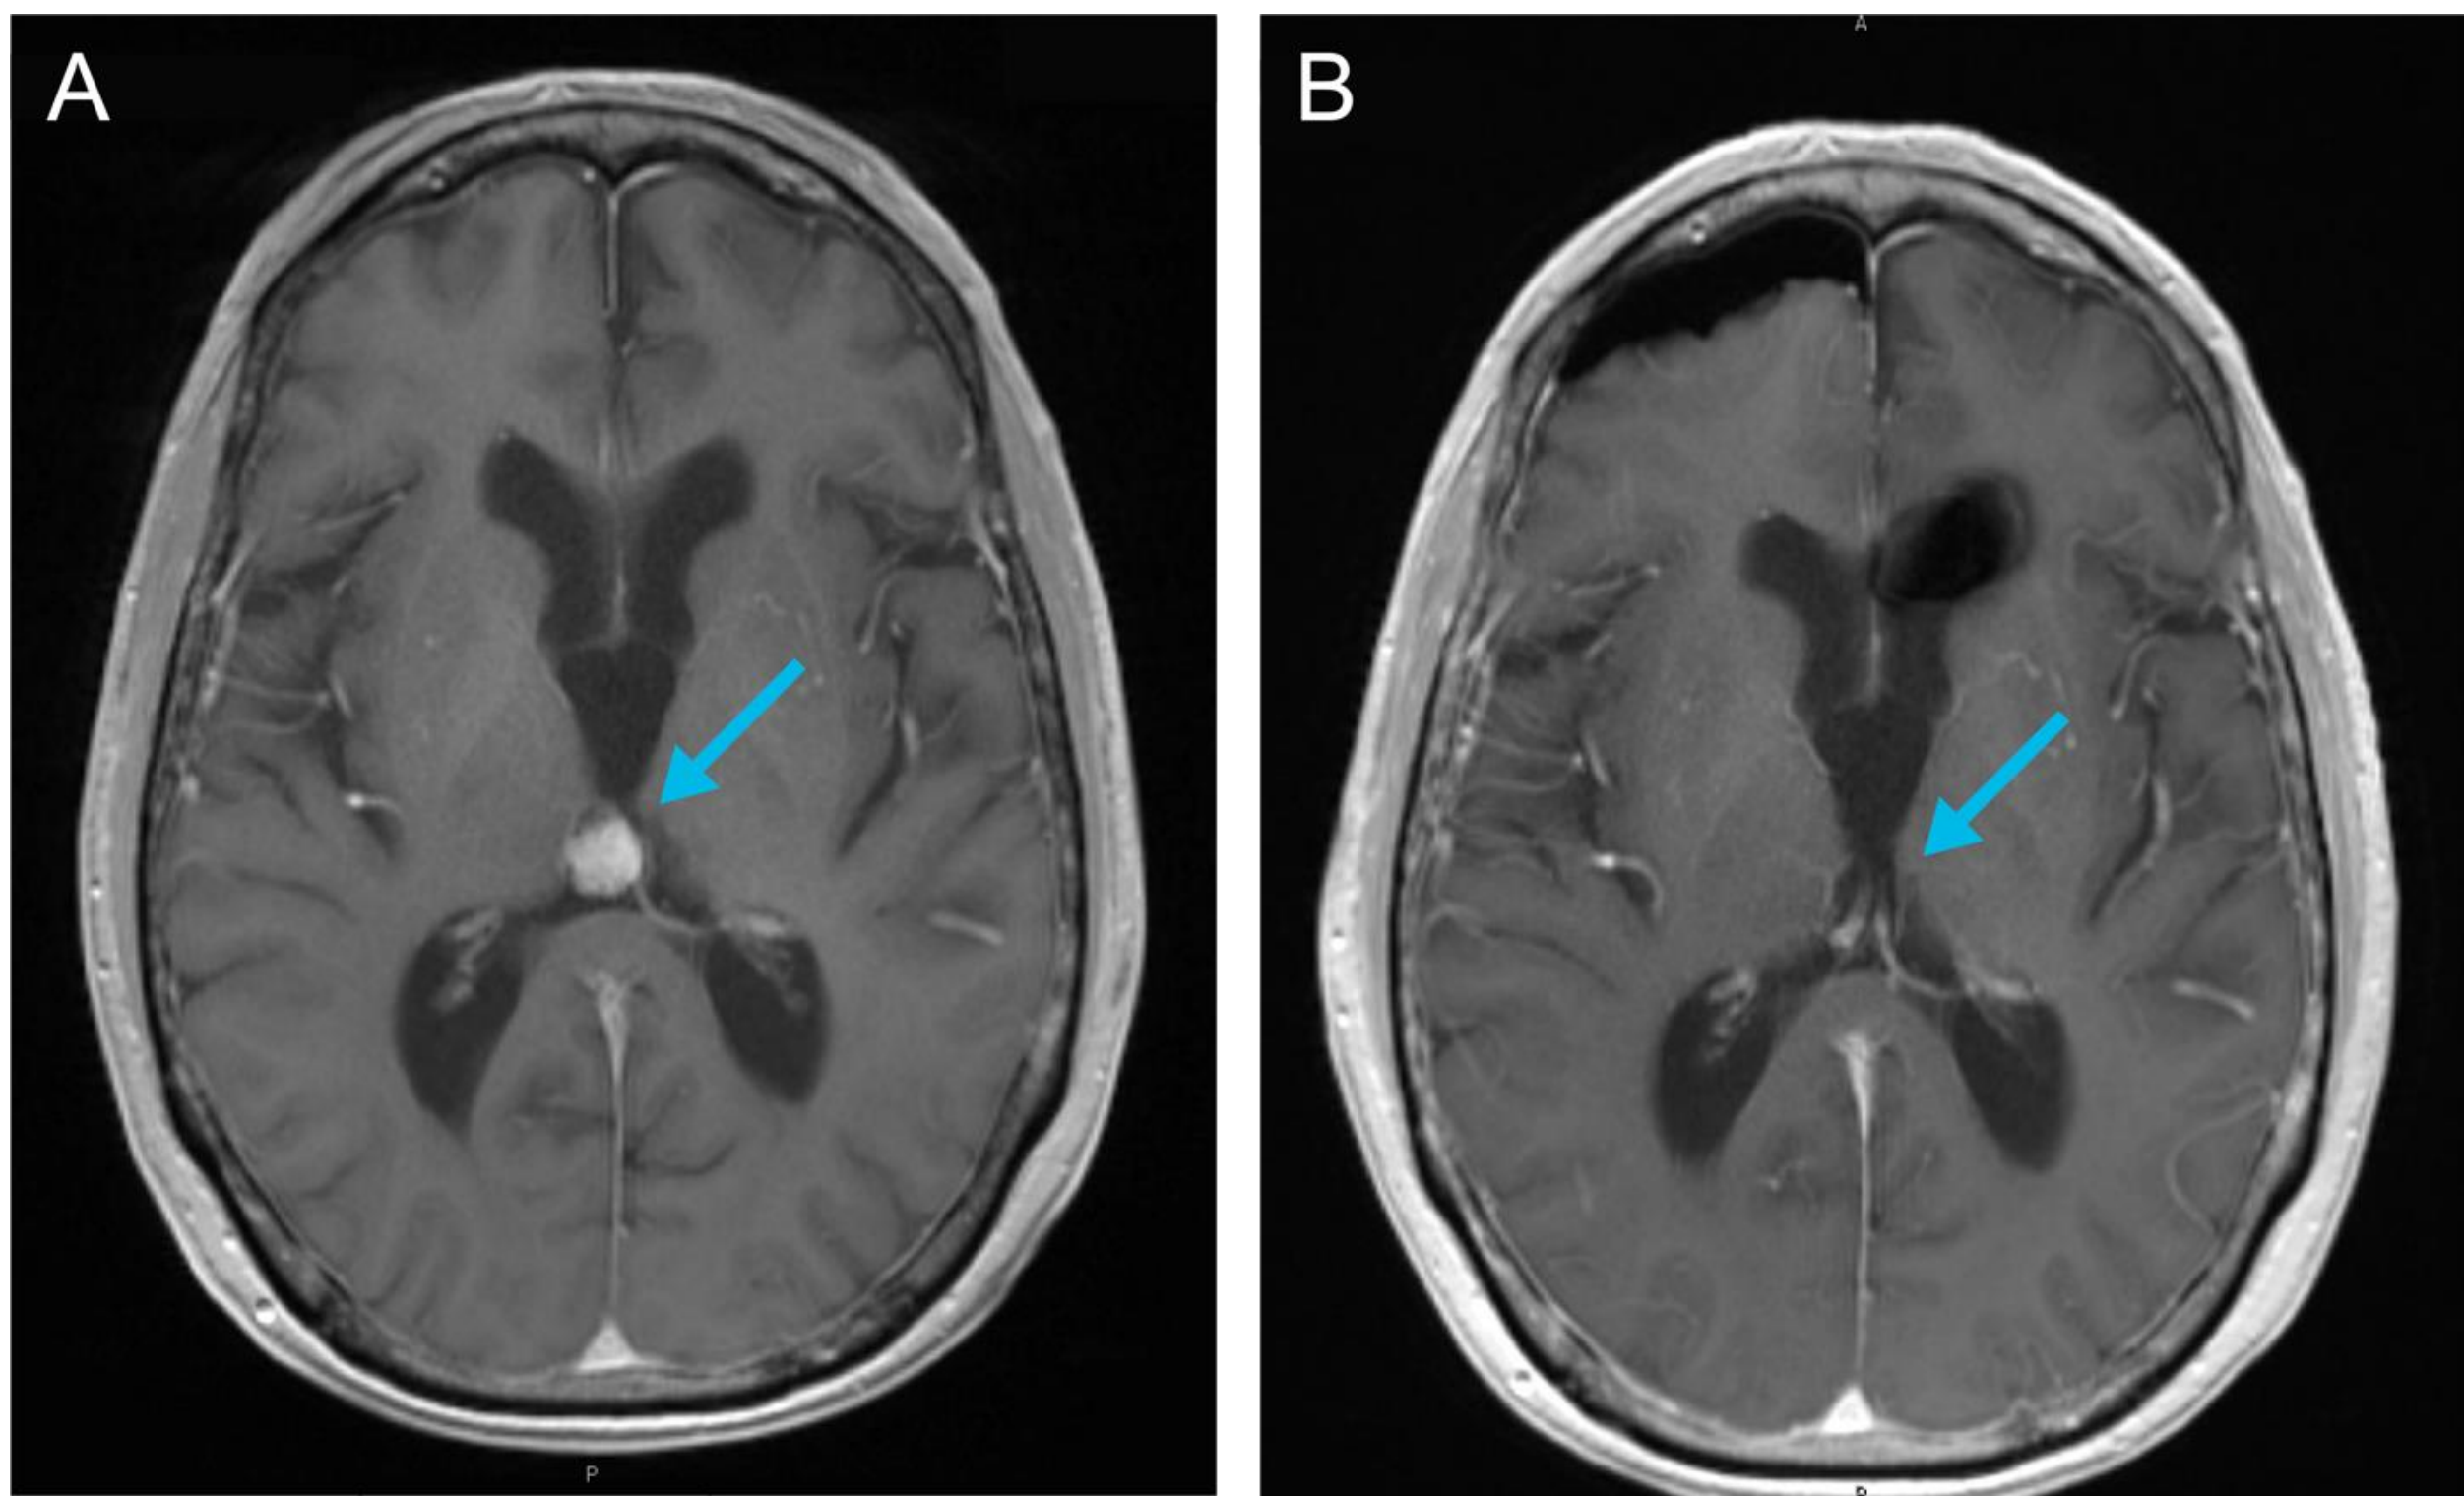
(A) Post-gadolinium contrast T1 MRI sequences pre- and (B) post-endoscopic resection of a pineal sarcoma transformed from a mixed germ cell tumor with germinoma and immature teratoma components originally managed with resection and RT in 1999. Tumor site indicated with blue arrow.
